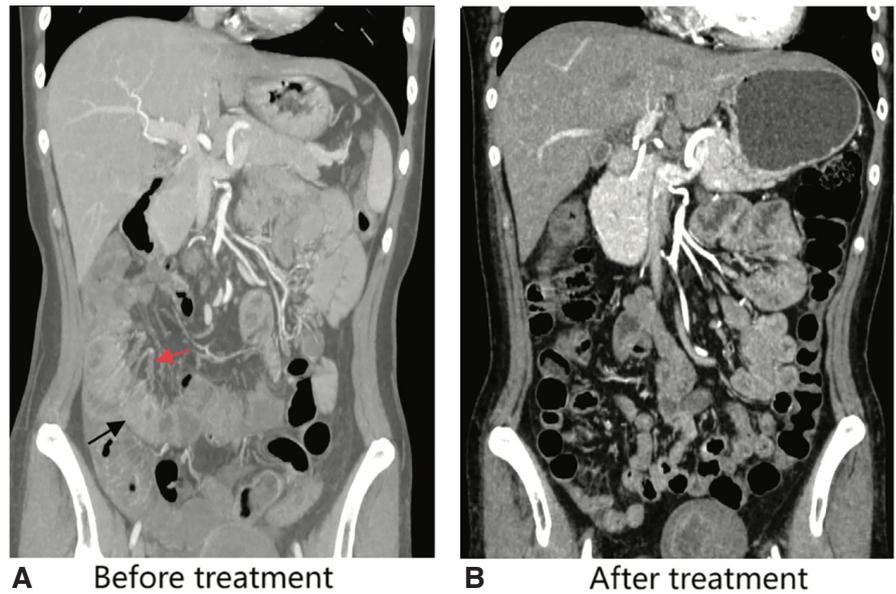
Abdominal contrast-enhanced CT before and after treatment.
